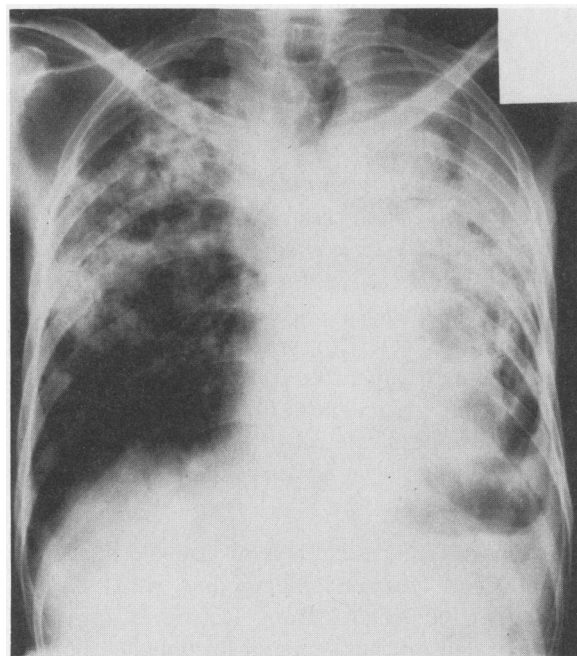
Roentgenogram of chest showing bilateral parenchymal infiltrates.
